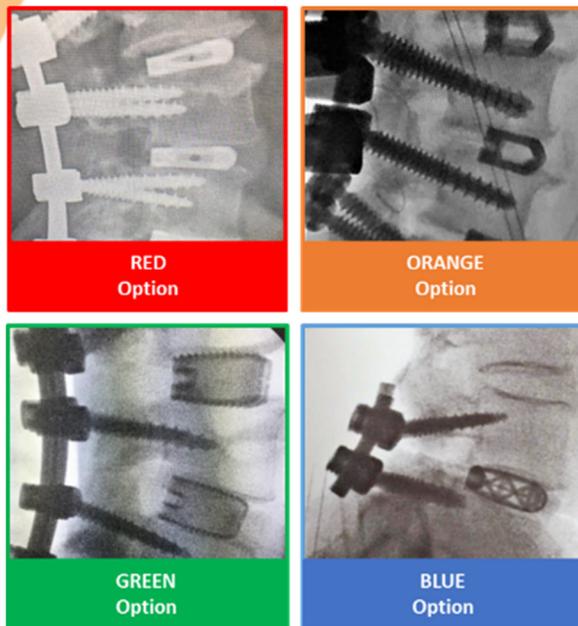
Radiographic images provided for surgeon ranking.
